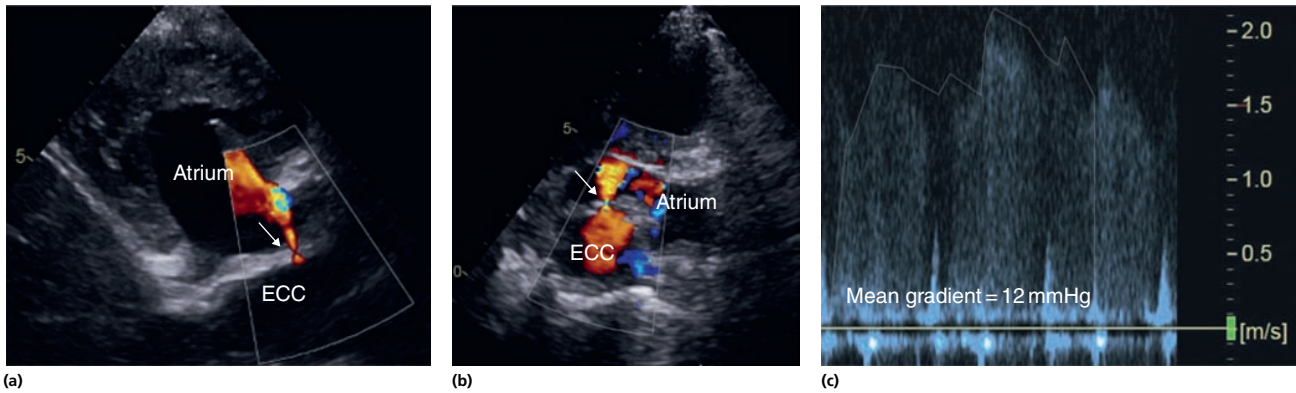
Fenestration in an extracardiac conduit (ECC). (a) The long-axis view of the conduit with the small fenestration as seen on color Doppler. (b) The fenestration in a short-axis cut through the conduit. The arrows point to the fenestration. (c) The spectral Doppler tracing measuring a mean gradient of 12 mmHg. This reflects the transpulmonary gradient (pressure difference between the Fontan and the atrium).
